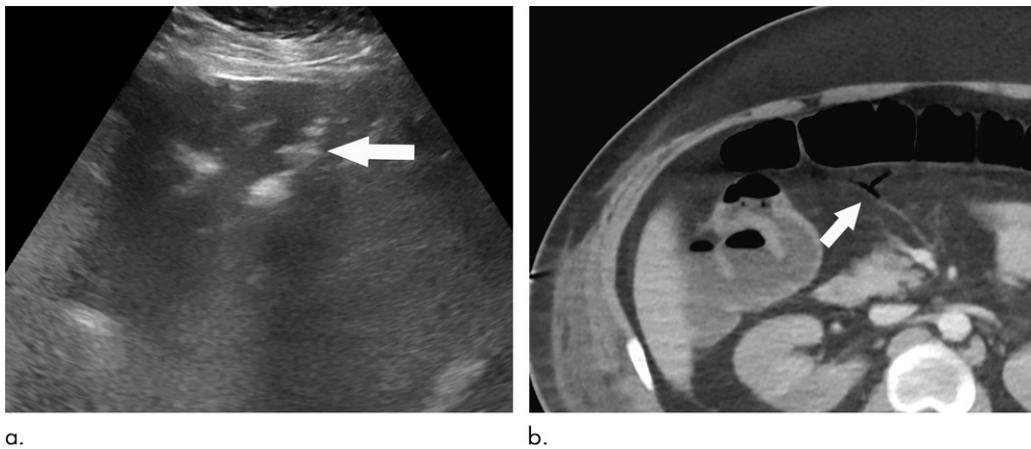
(a) Abdominal US obtained because of elevated liver enzyme level in a 34-year-old man incidentally shows peripheral echogenic branching foci (arrow) with dirty shadowing (*), in keeping with portal venous gas. (b) Subsequent CT image of the abdomen and pelvis with intravenous contrast material enabled confirmation of portal venous gas and shows gas in the transverse mesocolon vasculature (arrow). At laparotomy, patchy areas of yellow discoloration of uncertain origin are identified on the antimesenteric aspect of the transverse colon. Second-look laparotomy shows yellow discoloration of the stomach and no ischemia.
